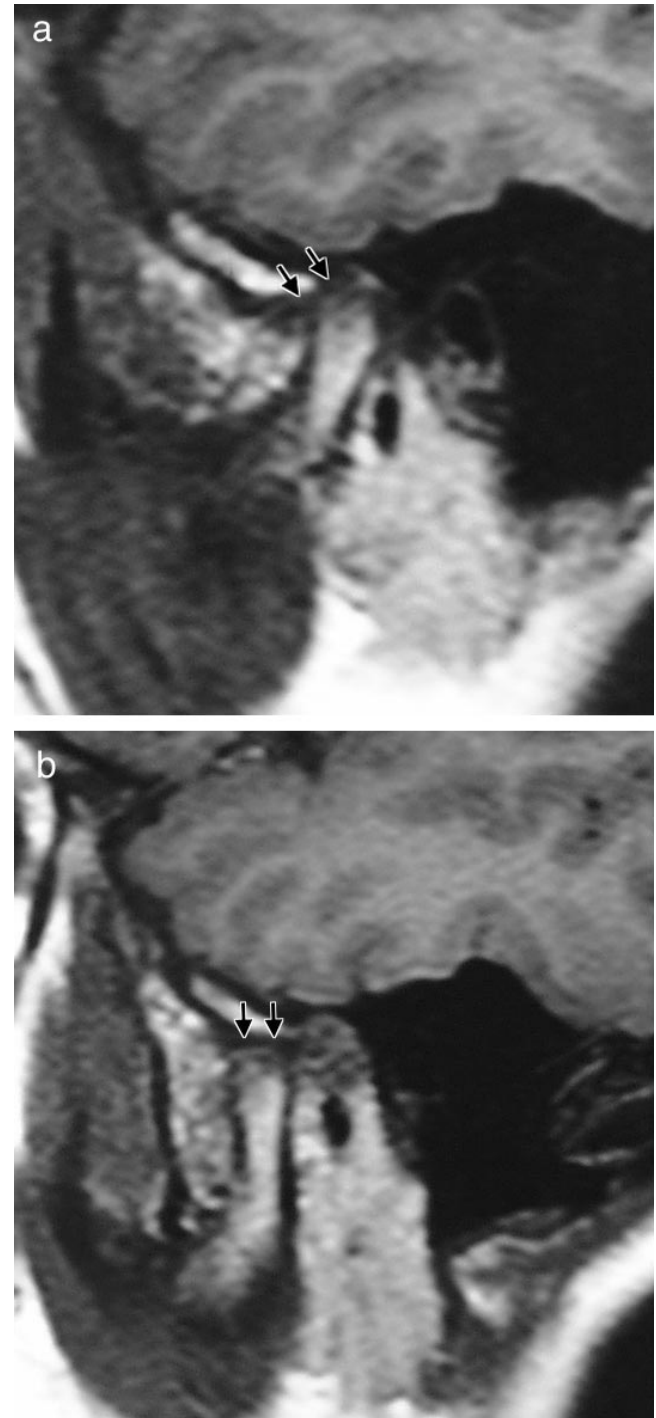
Normal temporomandibular joint. (a) Closed-mouth and (b) open-mouth oblique sagittal T1-weighted images showing normal position of disc (arrows).
